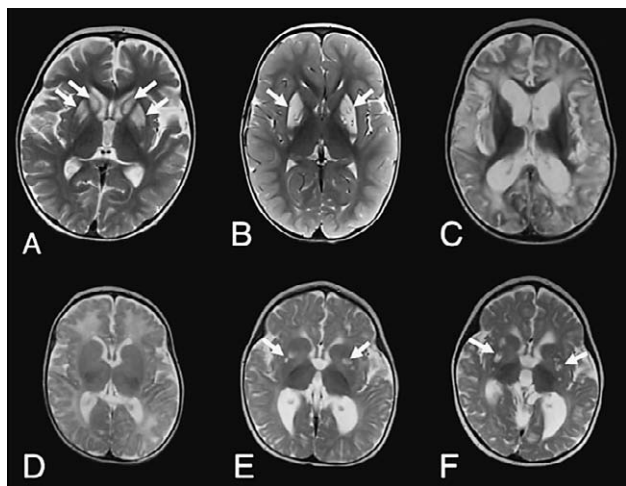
Axial T2-weighted brain MRI images.
